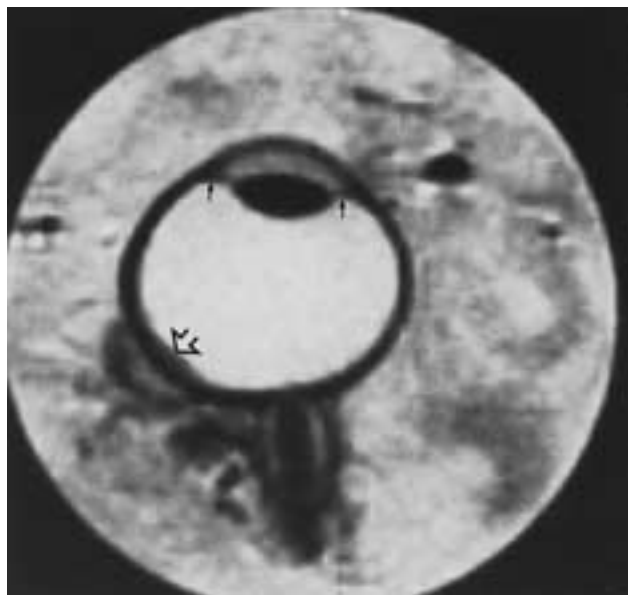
Uveal melanoma. T2-weighted MR image of an enucleated eye shows a hypointense posterior uveal melanoma (*hollow arrow*). Note the hypointensity of the lens and the hyperintensity of the vitreous humor. The ciliary body and lens zonules appear hypointense (*arrow*).
